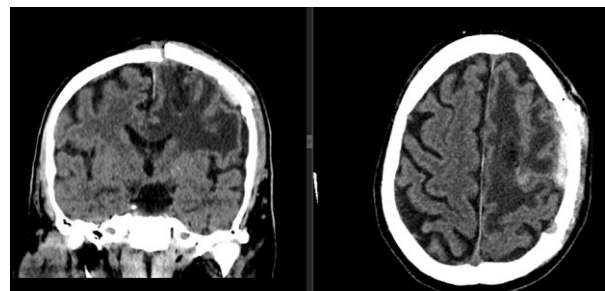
Postoperative cerebral CT scan that shows the complete removal of the abscess.
